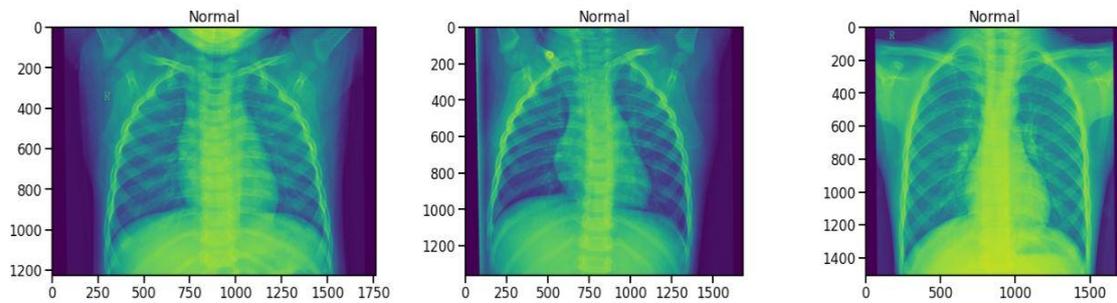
Chest X-ray images of normal peoples.
